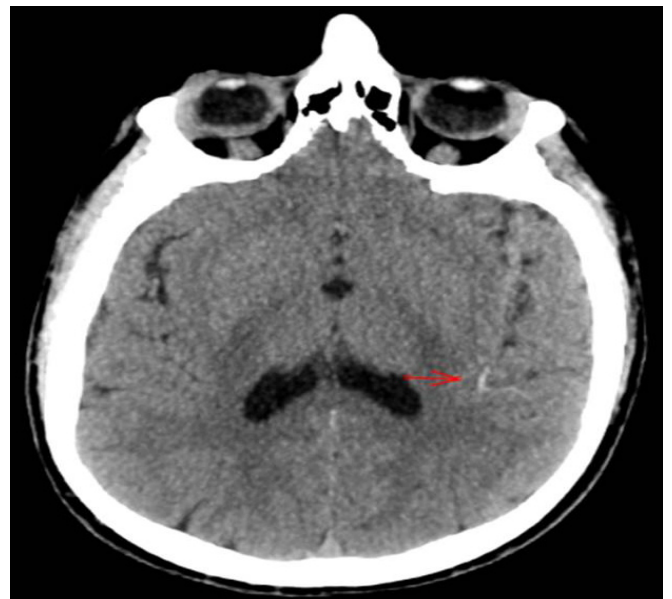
Transverse angled MIP CT showing a small hyperdensity in a left MCA branch (labelled with an arrow).
